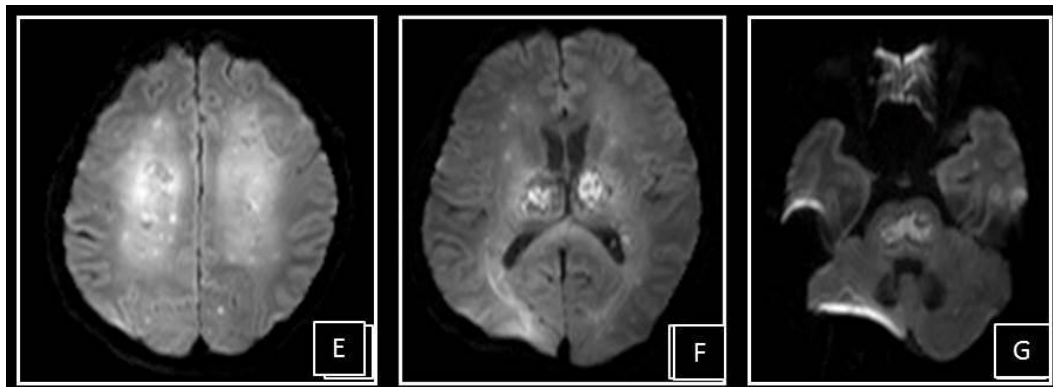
Dengue Encephalitis E, F, G: DWI E, F, G: Restricted diffusion on DWI in the hyperintensities shown in A, B, C, D (FLAIR images) of figure 3.
